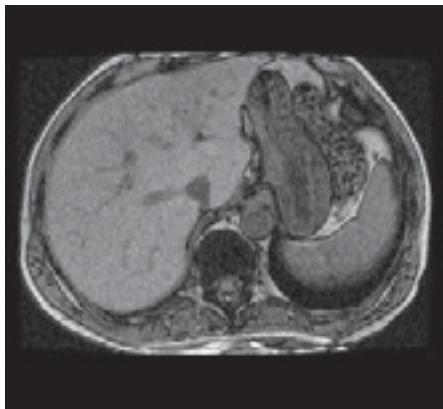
MRI magnitude image.
